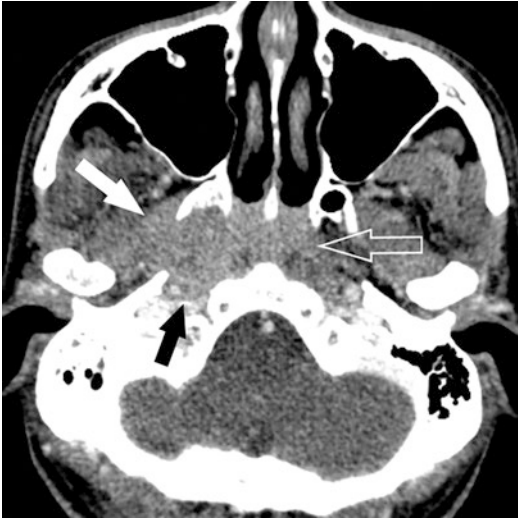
Nasopharyngeal lymphoma. Axial contrast-enhanced CT image shows enhancing homogeneous soft tissue on both sides of the nasopharynx (open arrow) with involvement of the right masticator space (white arrow) and right jugular foramen (black arrow)
